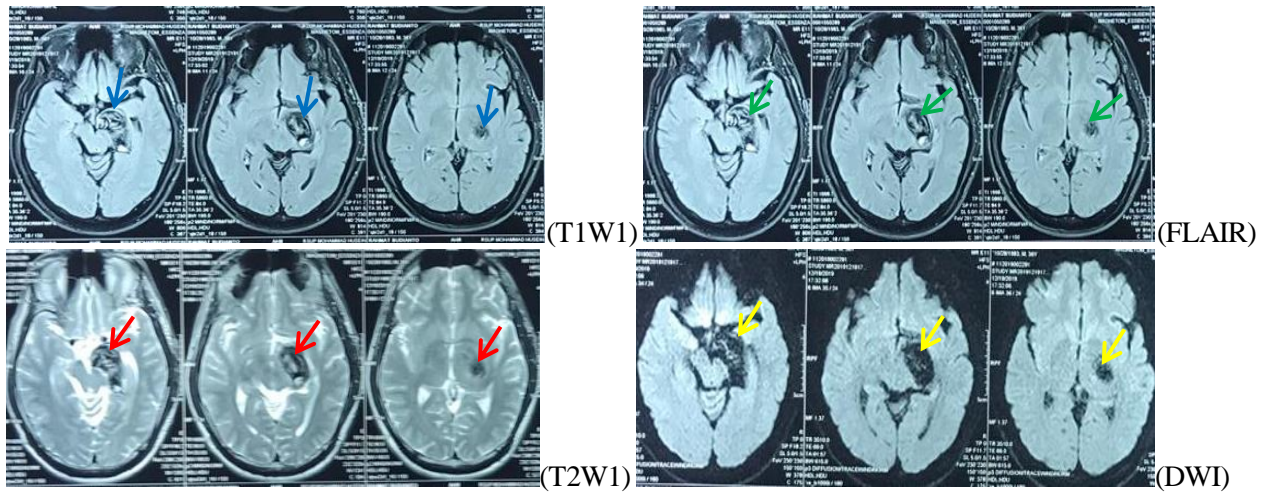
A head MRI showed a lesion measuring 4,06 x 2,66 x 3,70 cm of the left temporal on T1W1 (blue arrows), hypo-iso intensity of T2W1 (red arrows), predominantly hypointense on FLAIR (green arrows), unrestricted DWI (yellow arrows)
